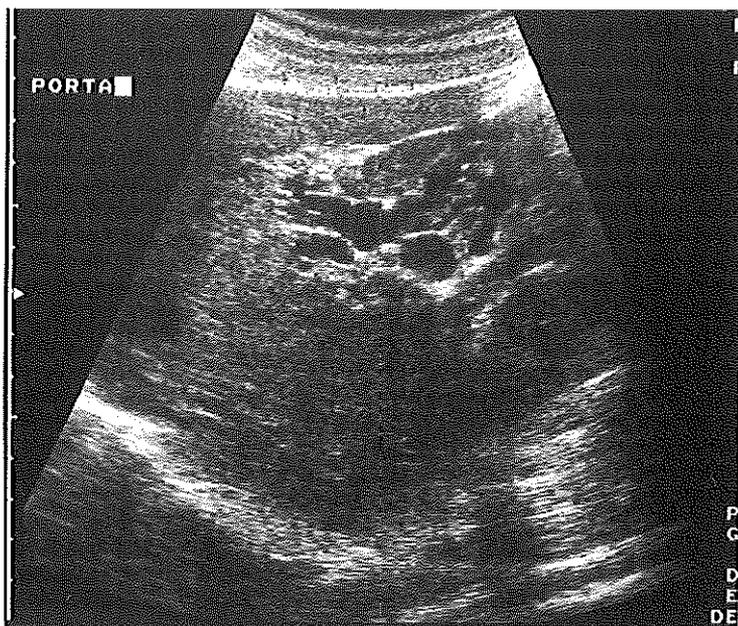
Ultrasonography of a portal cavemoma.
